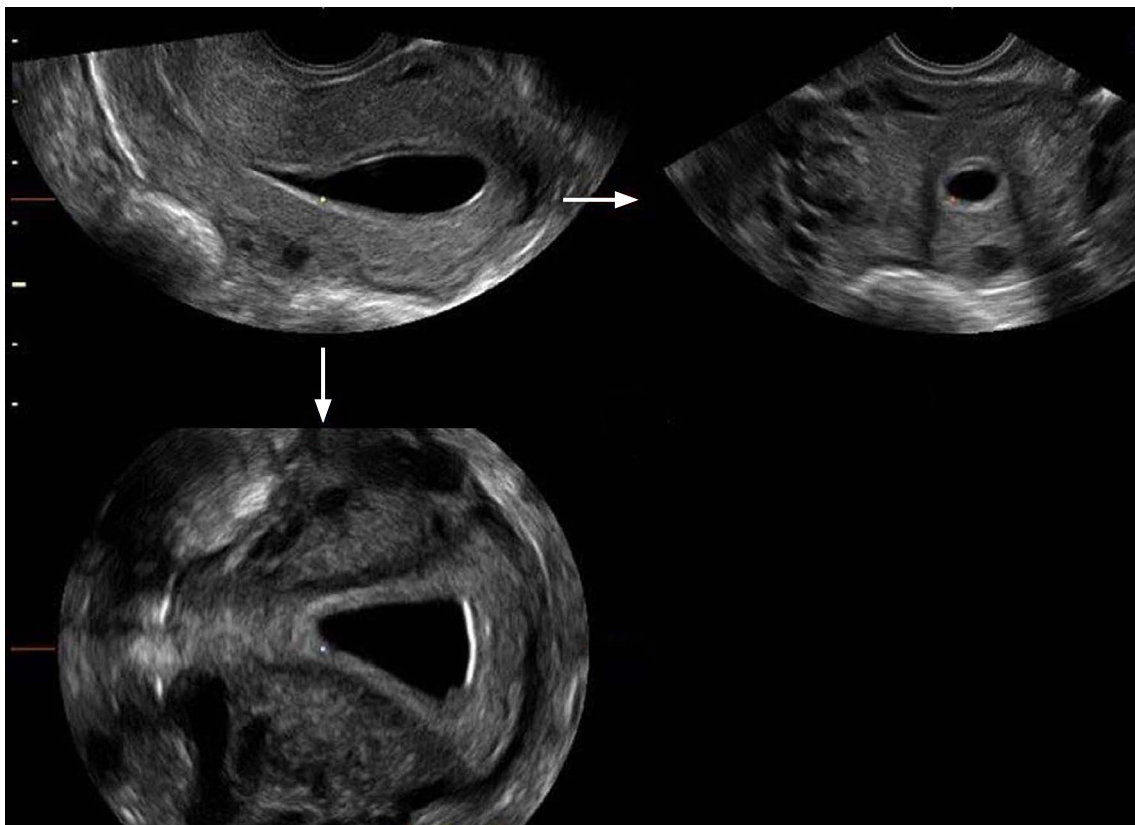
Three-dimensional transvaginal ultrasonography of a 26-year-old woman. Images are displayed in three planes including the plane of acquisition (upper left) and two reconstructed orthogonal planes derived from the volumetric data (upper right and lower left).
